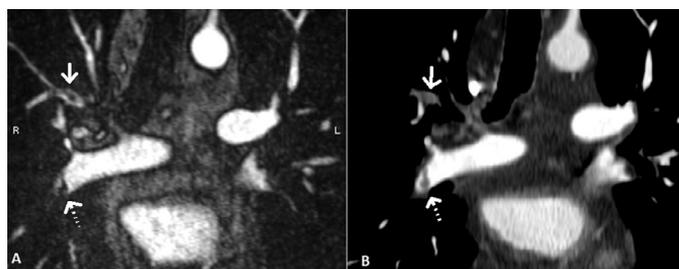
Same day CTPA and MRPA images of an 86 year old male patient with shortness of breath and elevated D Dimer level. Comparable CT vs. MR visualization of the subsegmental pulmonary arteries bilaterally on coronal thick MIP (a, b) and representative thin 5 mm MIP highlighting the left inferior pulmonary artery (c, d). No pulmonary embolism was found.
